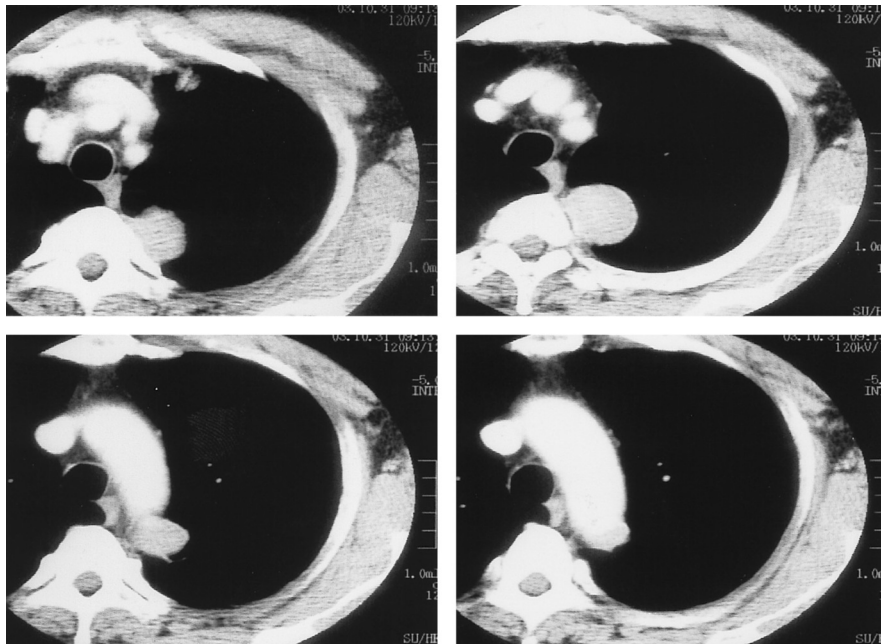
CT scan revealed a uniform iso density mass about 4 cm in diameter, with a well-defined border. After the intravenous contrast administration, a slight peripheral enhancement was seen around the mass.
